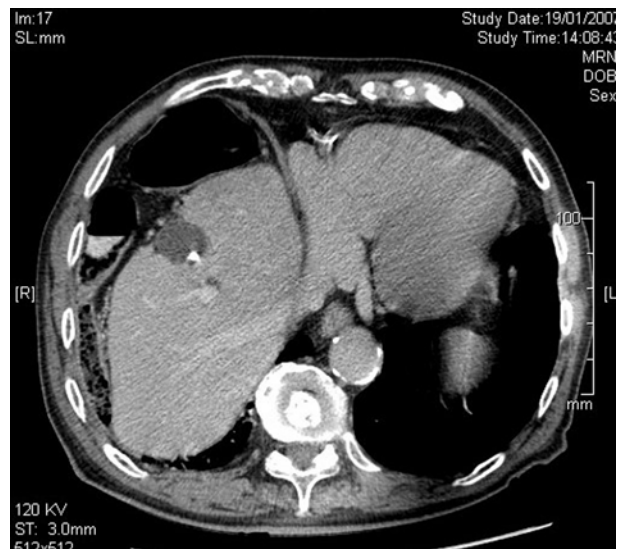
CT-scan with interposition of the colon between right liver lobe and diaphragm.
